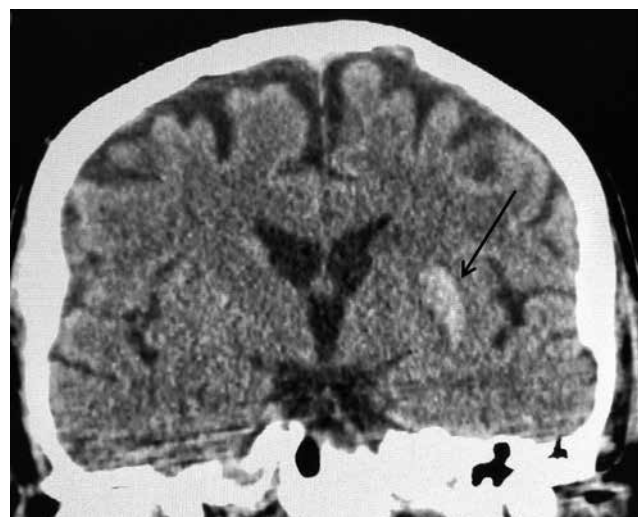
CT scan 1 day after endovascular thromboaspiration. The focus of hemorrhagic transformation (arrow)
